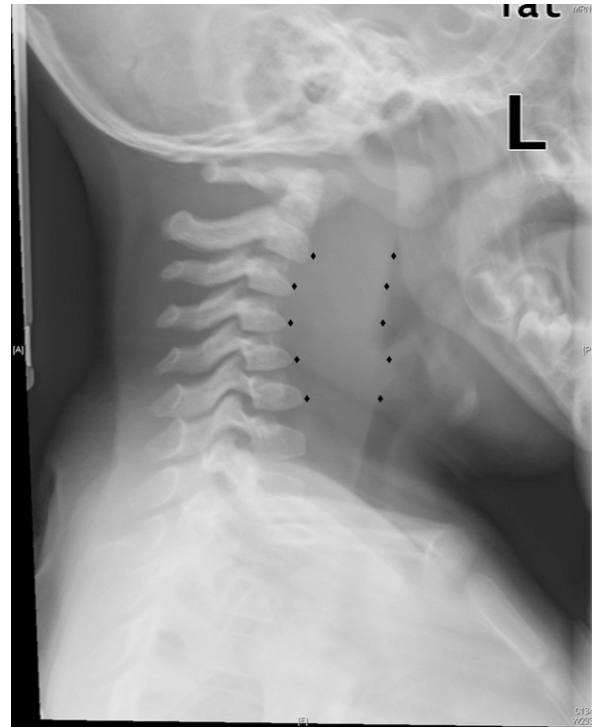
Lateral neck radiograph showing widening of the prevertebral soft tissue suggestive of retropharyngeal abscess.
